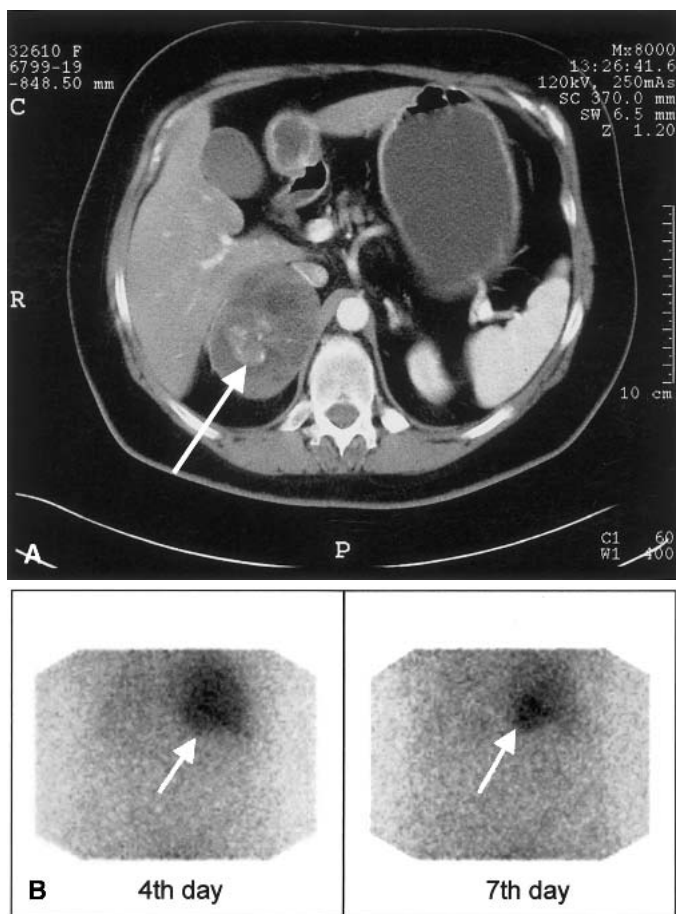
A. Abdominal CT scan showing a carcinoma of the right adrenal gland after IV contrast administration (patient no. 6). Abnormal impregnation is evident in the right lateral subcapsular region and partially in the central region. Inhomogeneous hypointense non-impregnated areas are a zone of intratumoral necrosis. Moreover, an enlarged metastatic intraabdominal lymph node is present. B. Anterior scan of adrenocortical scintigraphy in the same patient, performed the 4th and 7th days after ^{75}Se -6 α -methyl-19-nor-cholesterol administration. Significant, although inhomogeneous radiotracer uptake is evident.
